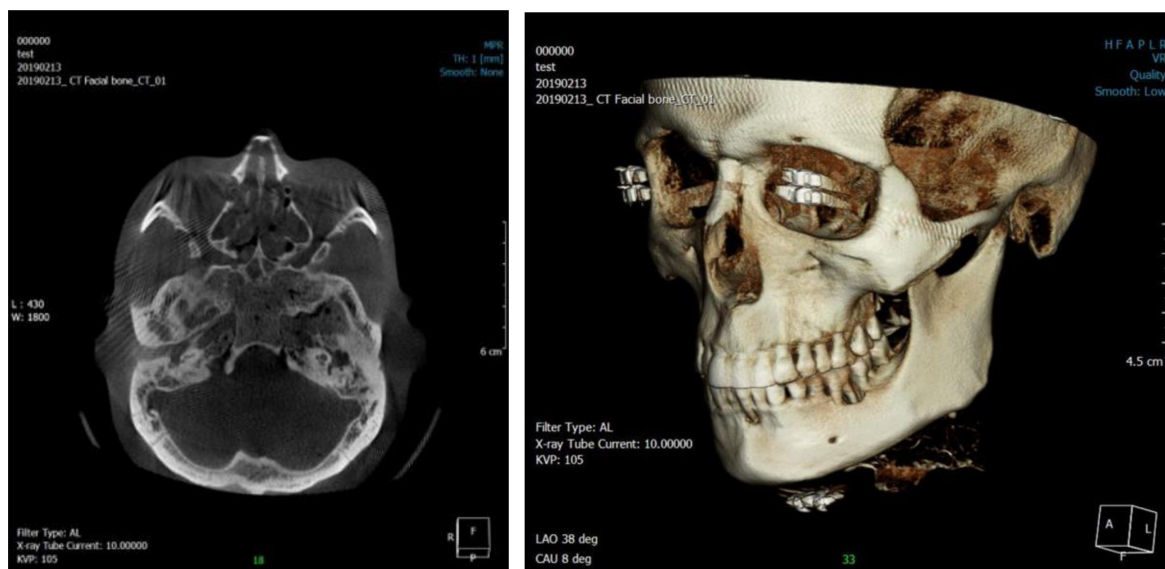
(Color online) 2D and 3D of Mobile CT 2D and 3D MDCT acquisition images for evaluation of medical image quality.
